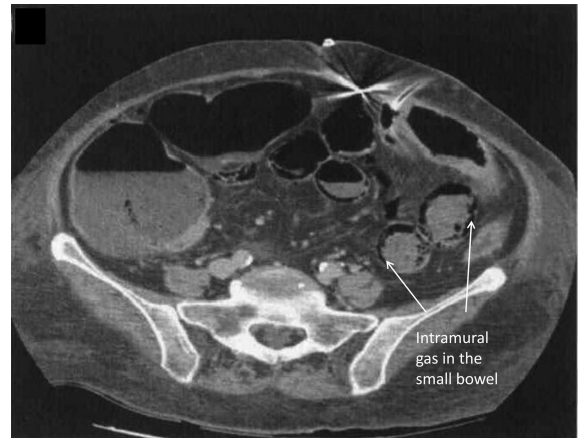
Pneumatosis intestinalis of the small bowel demonstrated on CT scan of the abdomen by intramural gas (arrows).
